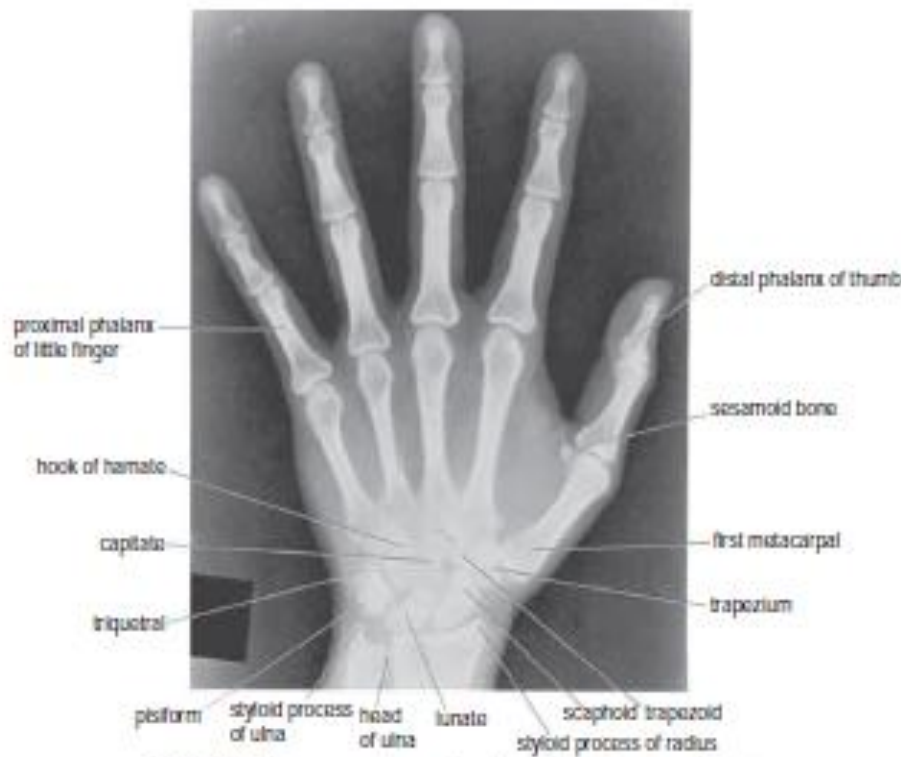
Posteroanterior radiograph of an adult wrist and hand.
